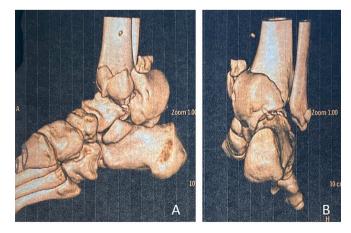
Preoperative CT-Scan of the right ankle: a fracture line gap in the neck of tallus (Hawkins fracture type III) and a fracture of the medial malleolus with no sign of soft callus (A) Lateral view (B) posterior view.
